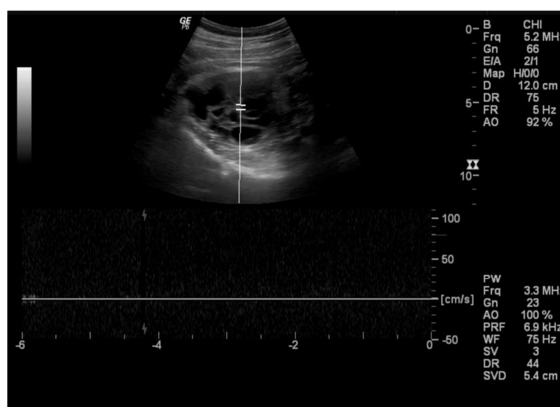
Hydatid cyst displaying absent vascularity on pulsed wave Doppler imaging.
